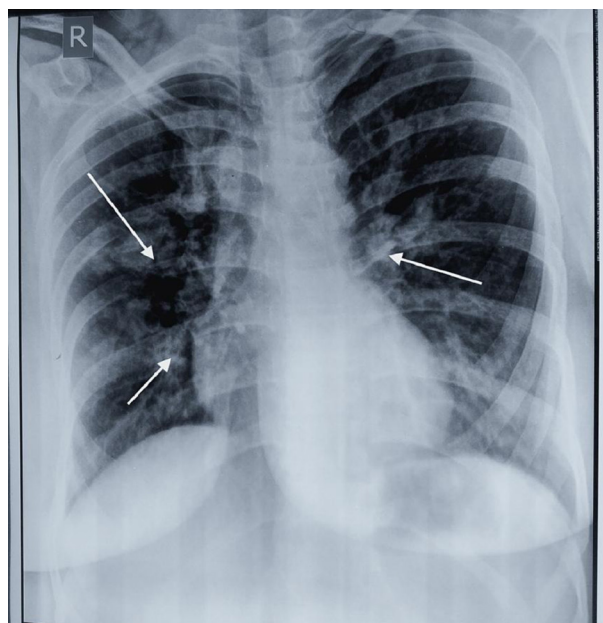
Chest X-ray of ABPA [source: ResearchGate]
